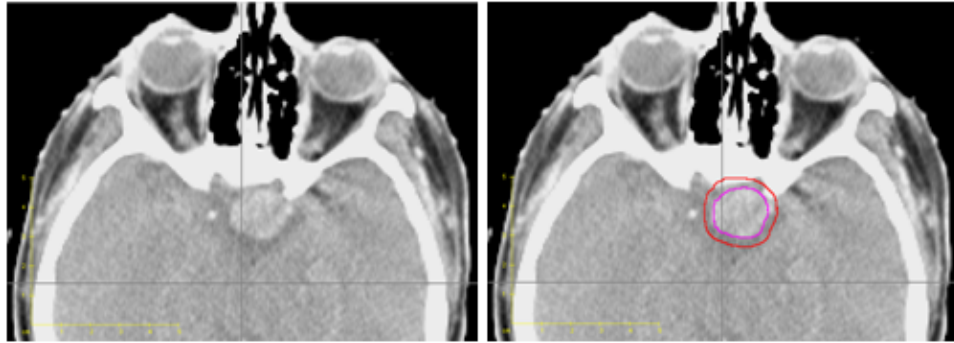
From left to right a CT image of a patient diagnosed with a brain tumor and the delineation of the CTV (purple) and the corresponding PTV (red). [This image is used under permission of the Hospital Universitario Puerta de Hierro Majadahonda, Madrid, Spain].
